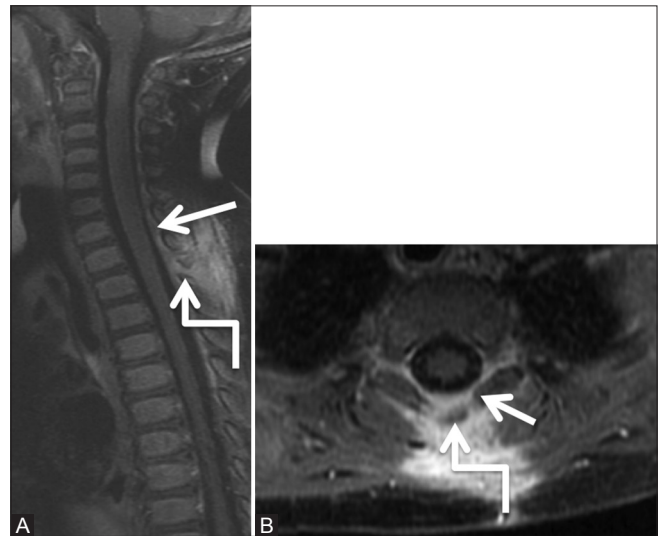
(A and B): Infective: Pyogenic abscess: Follow-up scan 6 weeks post-decompressive laminectomy and course of antibiotics: Post-contrast T1-weighted Sagittal (A) and axial (B) images show complete resolution of abscess. Minimal dural enhancement is seen (arrow). Note laminectomy defect at T1-2 level (elbow arrow)
